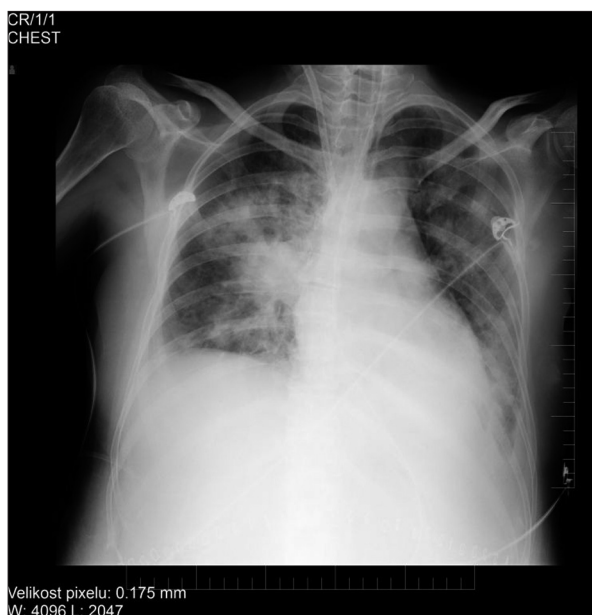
Chest x-ray: pulmonary edema.
